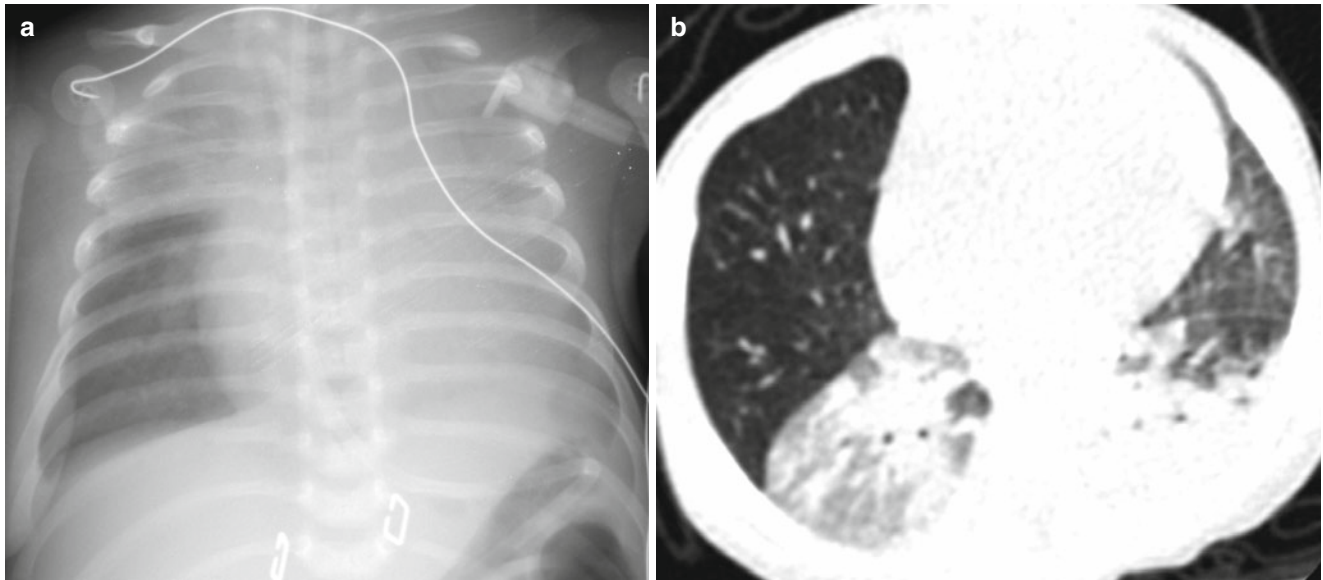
(a, b) Congenital lobar hyperinflation. Plain chest radiograph (a) and axial CT image (b) show the hyperlucent and hyperinflated right middle lobe that was proven as congenital lobar hyperinflation
